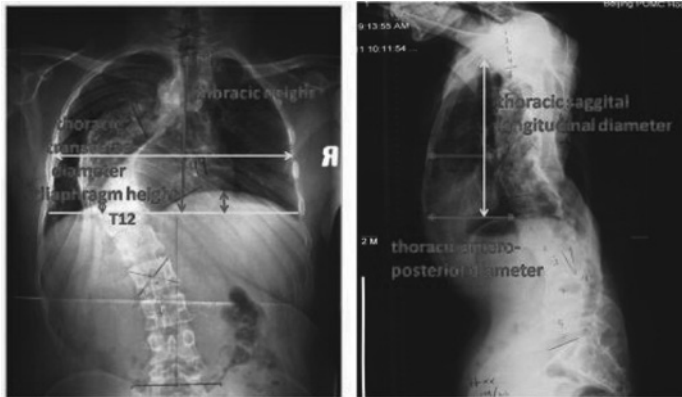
Demonstration of measurements performed on the posteroanterior(left) and lateral view (right) X-ray of a patient. Thoracic parameters include: thoracic height (the distance from T1 to T12), left and right diaphragm height (the distance from T12 center horizontal line to the diaphragm dome), thoracic transverse diameter (the distance of bilateral costal margin in apical vertebra level), thoracic anteroposterior diameter (the distance from chest wall to the anterior margin of vertebra in diaphragm dome level or apical vertebra of kyphosis level), and thoracic sagittal longitudinal diameter (the distance from apex pulmonis to the diaphragm dome).
